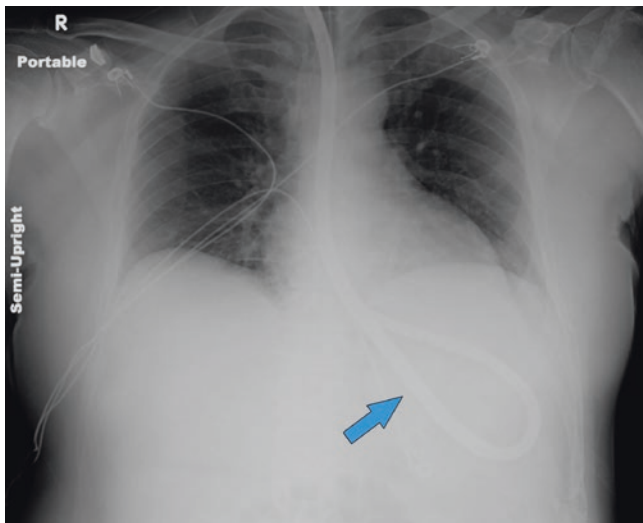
Radiographic confirmation of the tube inside the stomach
